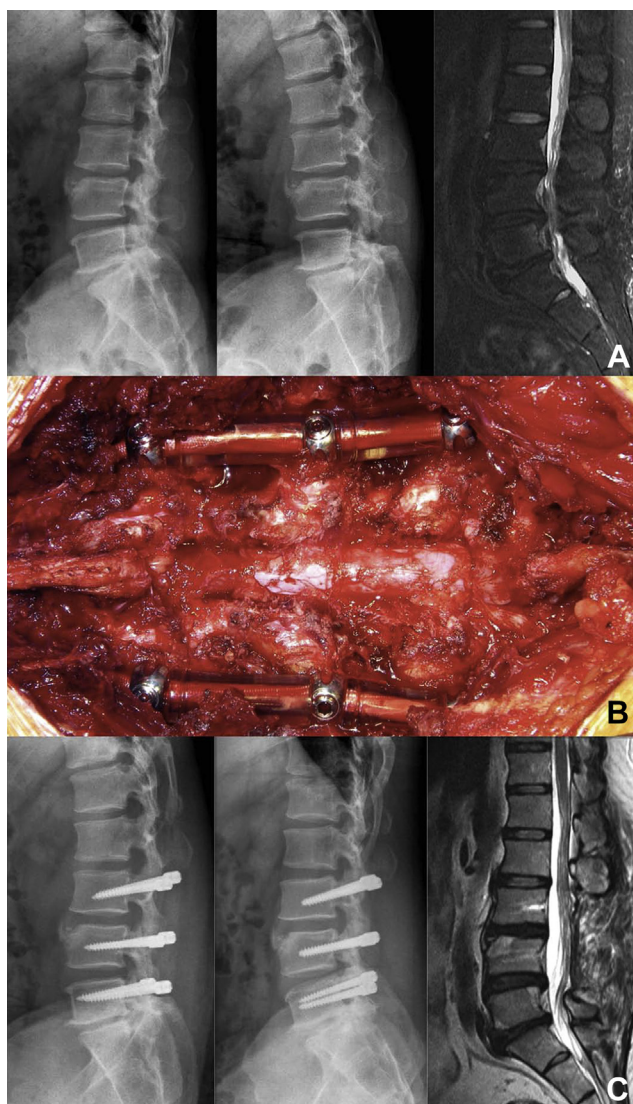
Example of a patient who underwent Dynesys implantation. (A) L-spine magnetic resonance imaging (MRI) and lumbar spine X-ray were performed, and revealed lumbar spondylosis and severe lumbar stenosis. (B) Intraoperative imaging showed the traditional total laminectomy and implantation of Dynesys with preservation of all facet joints. (C) At the 2-year follow-up point, the radiological images showed adequate decompression for lumbar stenosis, and no degeneration or instability was noted over the adjacent levels.
